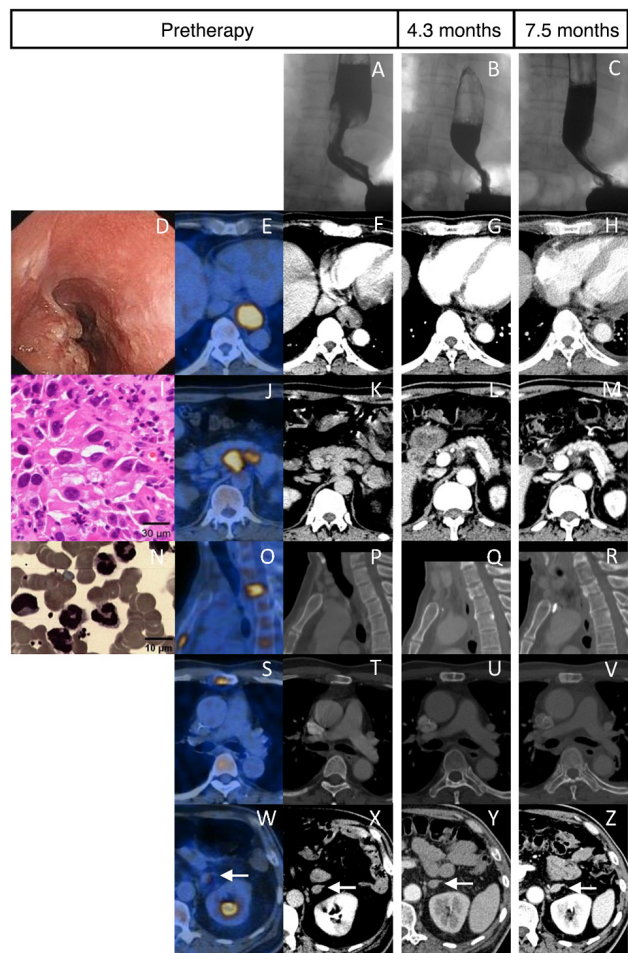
Radiographic (A-C, E-H, J-M, O-Z), endoscopic (D), pathologic (I) and bone marrow cytologic (N) characteristics at diagnosis, 4.3 and 7.5 months.
